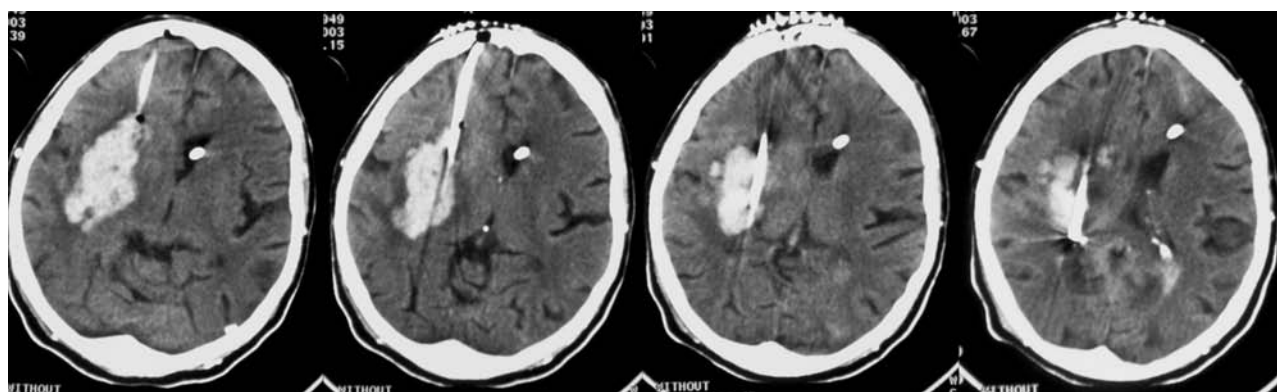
Head CT scan showing intraclot catheter placement in a patient with a right basal ganglia ICH (patient 5). Note the spatial relationship between the catheter and the long axis of the blood clot.
